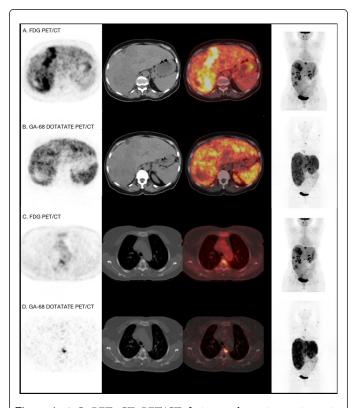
A,C: PET, CT, PET/CT fusion and maximum intensity projection (MIP) images of ¹⁸F-FDG PET/CT. B,D: PET, CT, PET/CT fusion and MIP images of ⁶⁸Ga-DOTA-TATE PET/CT.
